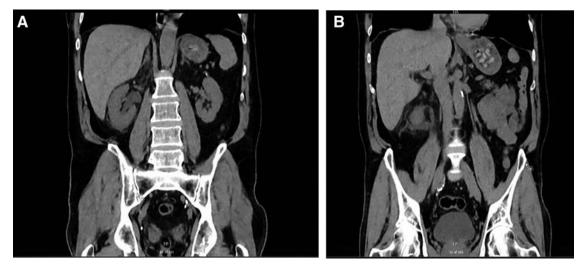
(A) Right hydronephrosis with no visible source of obstruction on CT. (B) Significant right perinephric stranding.
